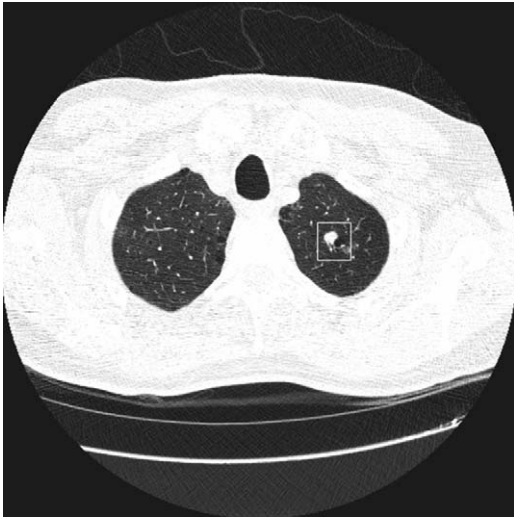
Axial CT image with a small pulmonary nodule outlined.
